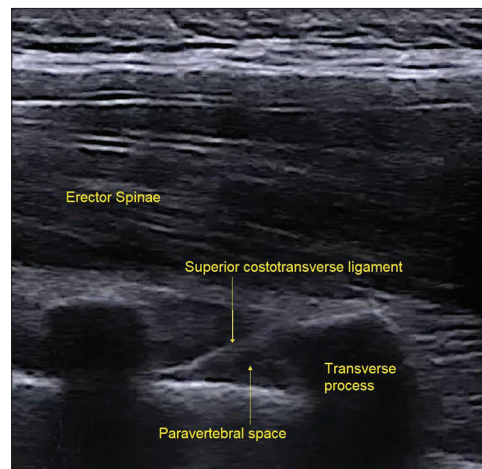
Ultrasound image of paravertebral space
